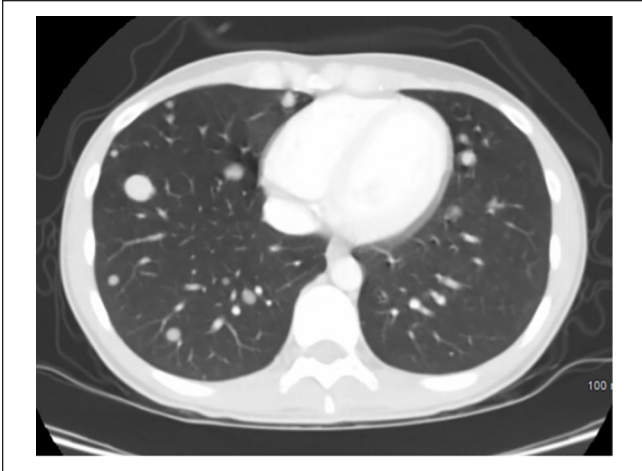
Computed tomography (CT) scan of the chest with contrast showing multiple pulmonary nodules.
